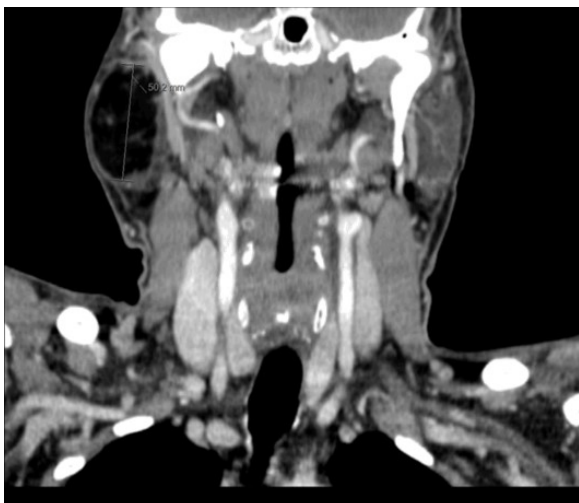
CT scan - Right Parotid Gland Lipoma
